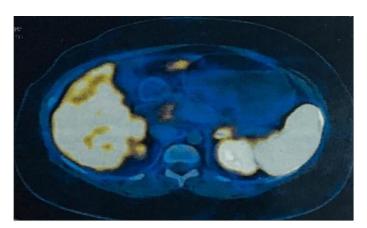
DOTANOC PET CT image suggestive of Nesidioblastosis
